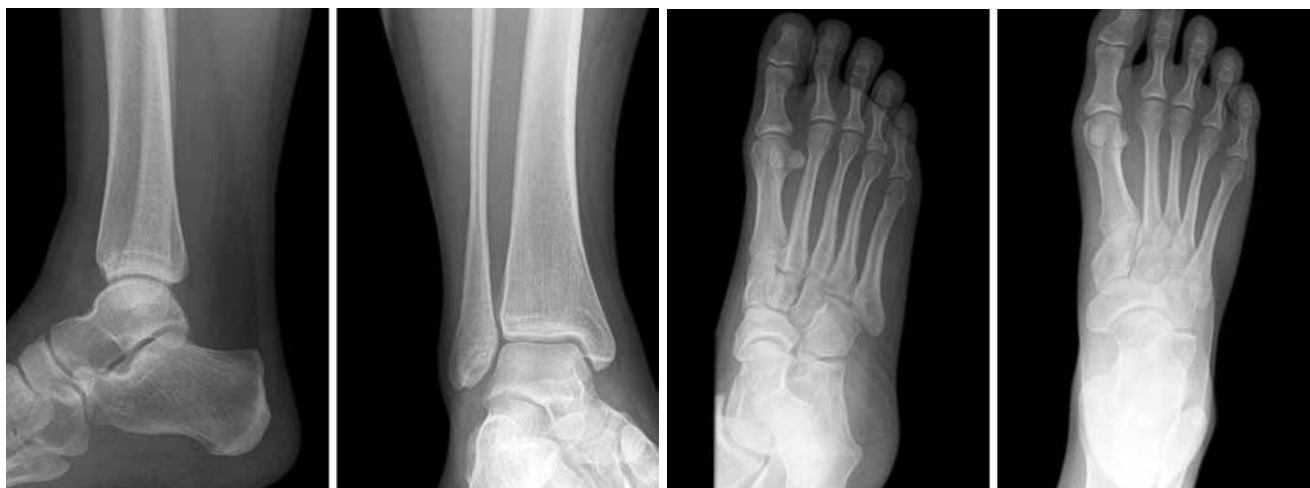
Preoperative plain radiographs of patient's right foot and ankle showing some irregularity of the talar head
